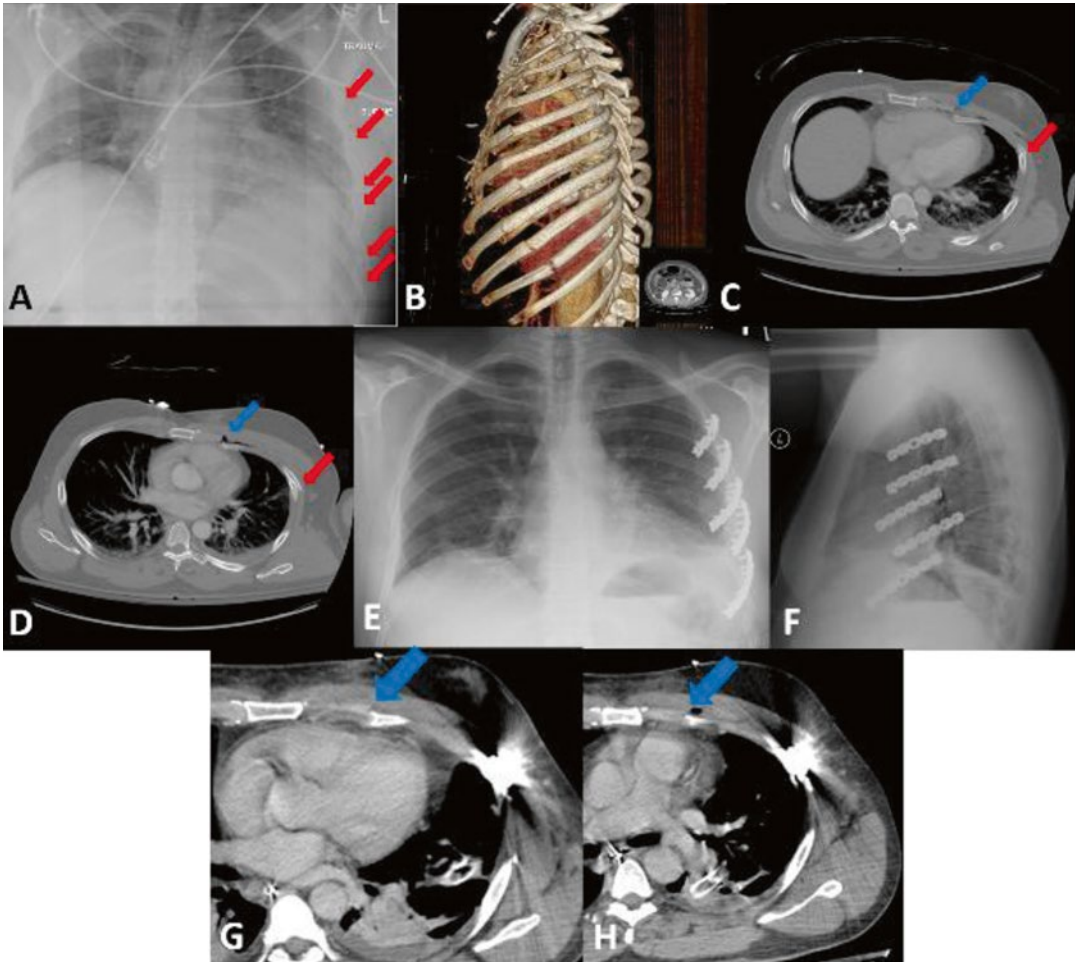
(a and b) Preoperative AP chest radiograph and 3D CT reconstruction demonstrating multiple displaced, left-sided, anterolateral rib fractures (*red arrows*). (c and d) Axial CT images demonstrating displaced anterolateral rib fractures (*red arrows*) and costochondral dislocations (*blue arrows*). (e and f) Postoperative PA and lateral
